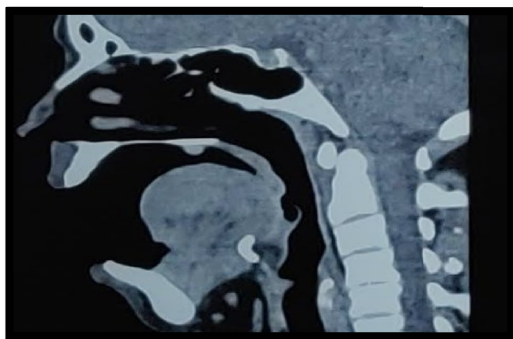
Computed Tomography Shows Extension of lesion with bony Erosion to palate.
